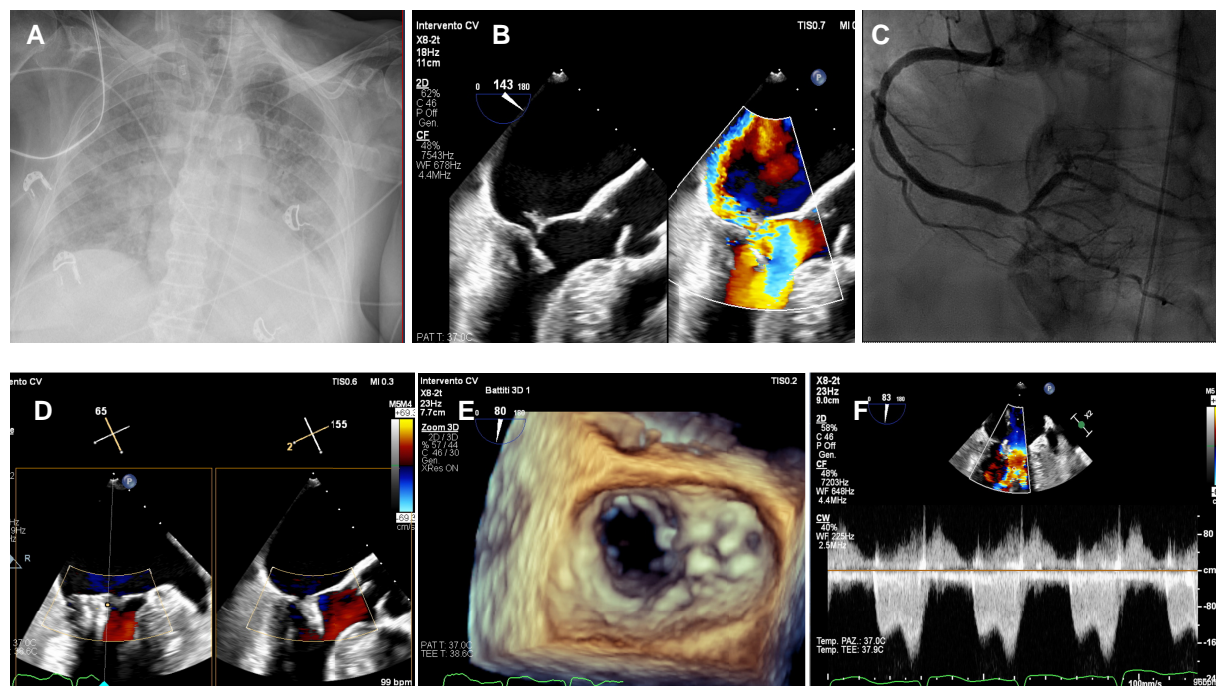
(A) Chest X-ray demonstrating acute pulmonary oedema. (B) Transesophageal (midesophageal long axis) echocardiography showing posterior mitral flap prolapse due to posteromedial papillary muscle rupture, generating severe eccentric mitral regurgitation (quantitative method). (C) Coronary Angiography. Right coronary artery in the left anterior oblique view, showing moderate stenosis in the middle segment and critical lesion in the distal segment with TIMI III flow. IABP positioned in the descending thoracic aorta. (D and E) 2D transesophageal echocardiography (two midesophageal chambers) and 3D echocardiography, showing the result after percutaneous edge-to-edge mitral valve repair with mild mitral regurgitation. (F) Mean mitral gradient after Mitraclip implantation.
